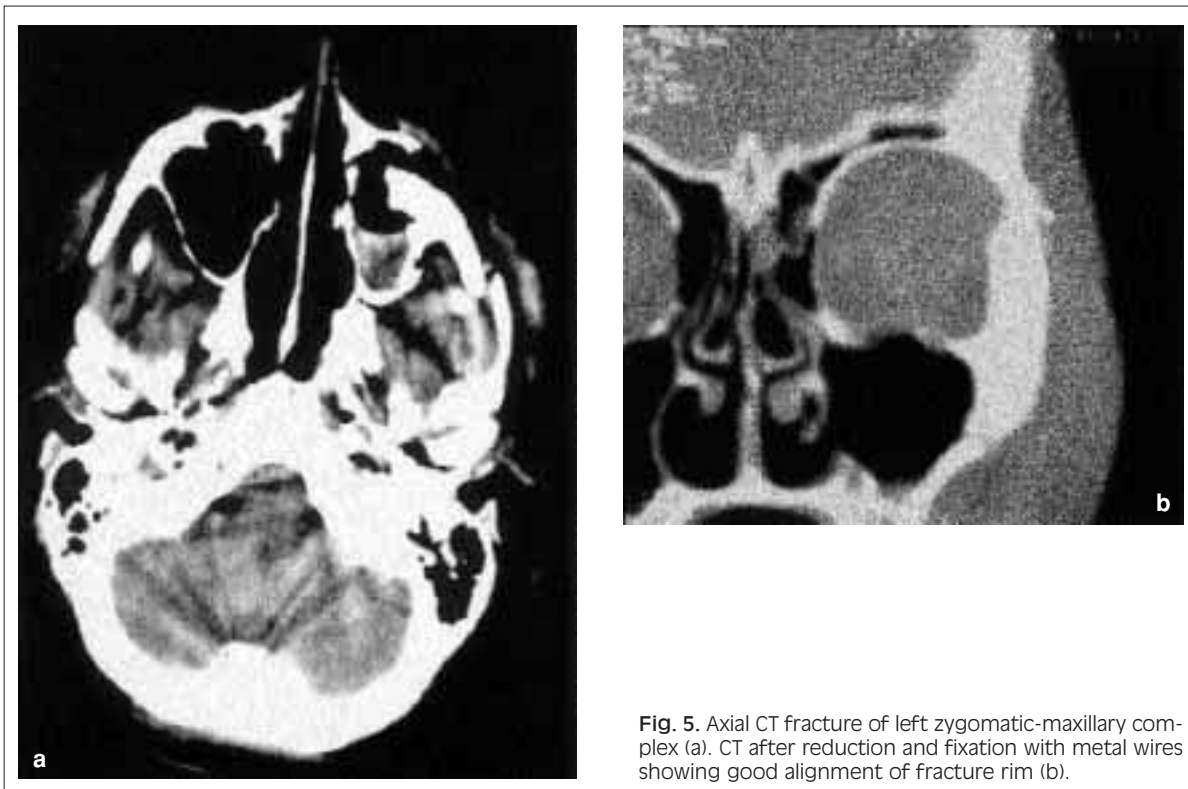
Axial CT fracture of left zygomatic-maxillary complex (a). CT after reduction and fixation with metal wires showing good alignment of fracture rim (b).
